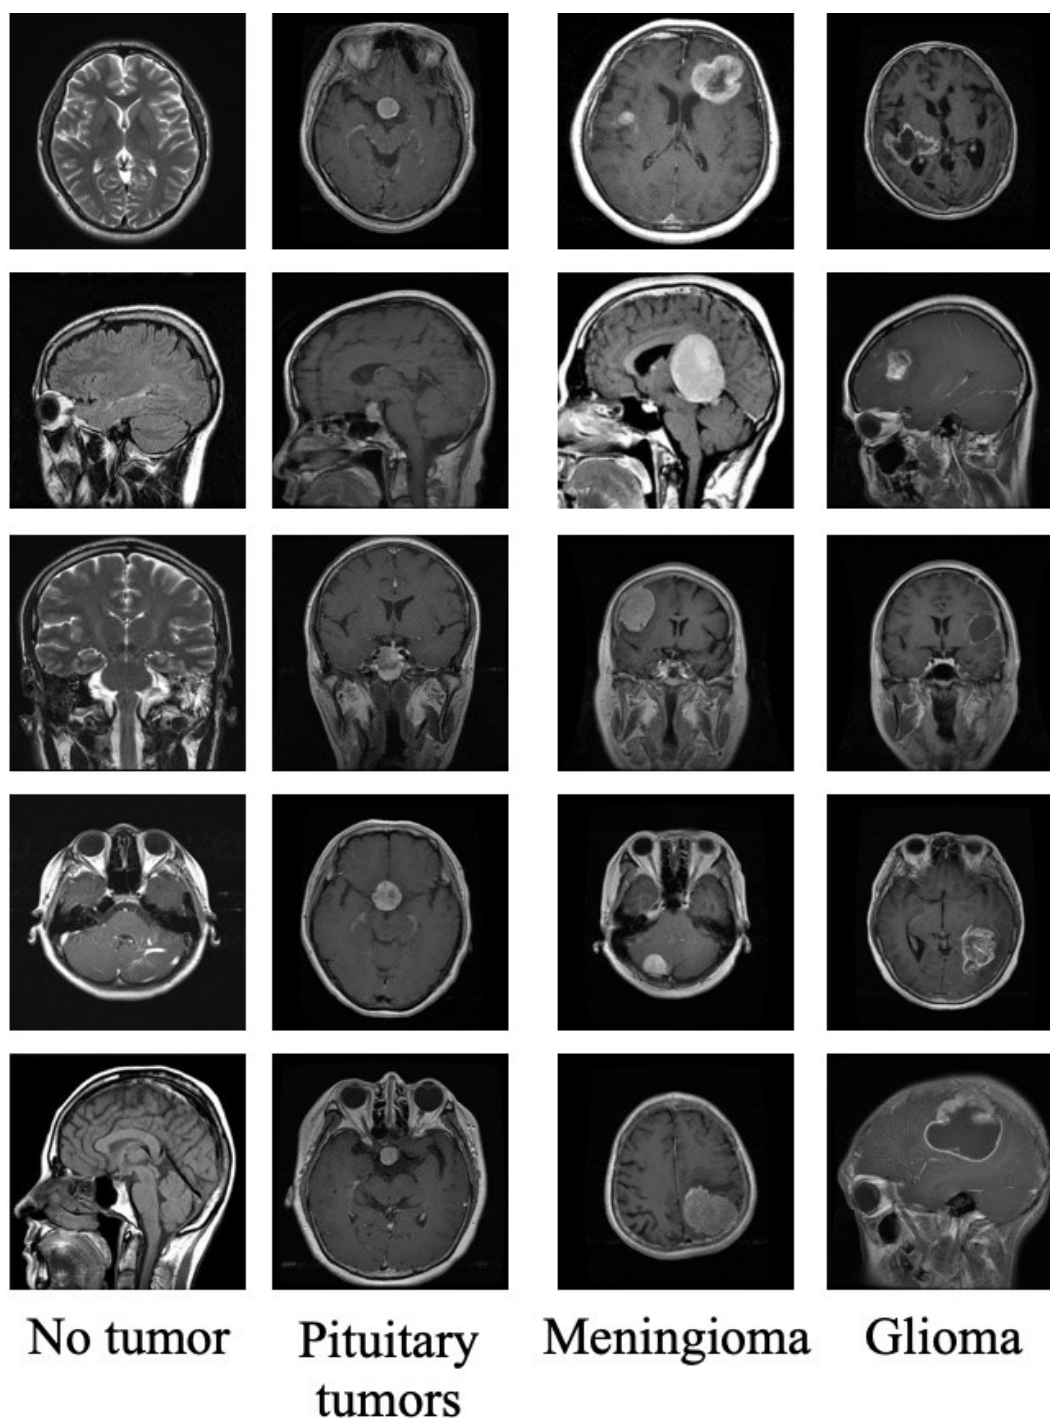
Sample Brain MRI Images of the Four Classes of Brain Tumors in This Study
